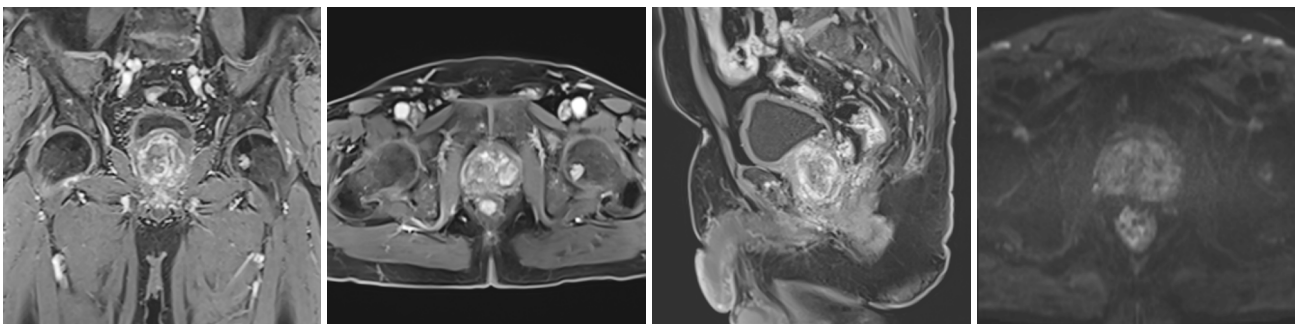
MRI findings at 3 months after the operation: the PV was approximately 3.4 cm × 3.1 cm × 4.1 cm, the soft tissue mass shadow was further reduced than before, the region with high signal intensity of DWI sequence almost disappeared. MRI, magnetic resonance imaging; DWI, diffusion-weighted imaging; PV, prostate volume.
